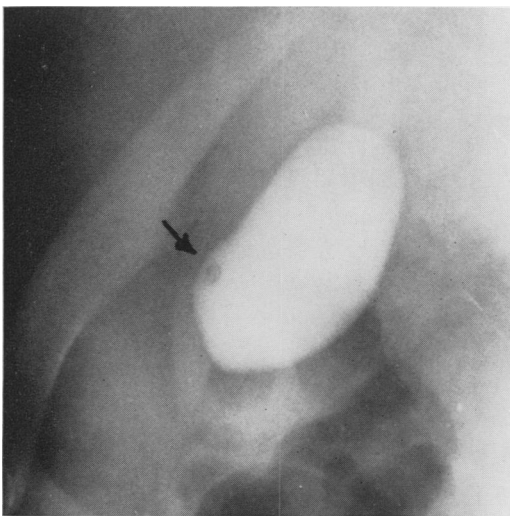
Roentgenogram shows radiolucent shadow of adenoma of gallbladder.
